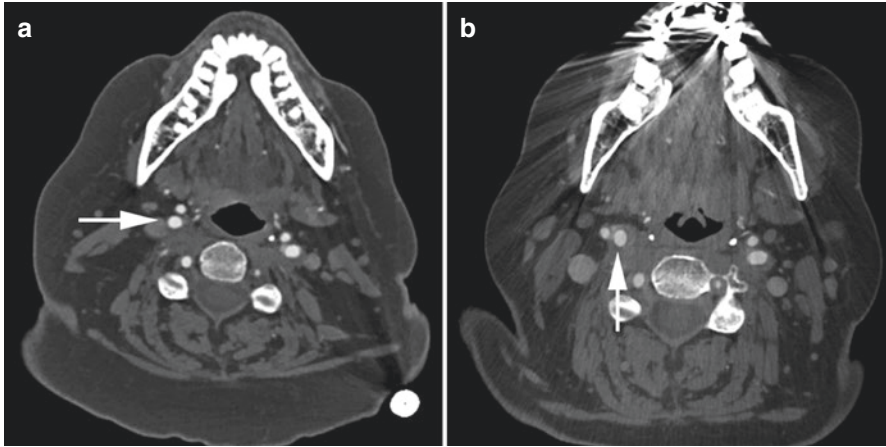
Carotid bifurcation rotation. Two CTA scans 6 months apart showing rotation of the right carotid bifurcation within the carotid sheath. Initially, the right ICA (arrow) was located posterolateral to the ECA (a). On the second scan, the right carotid rotated such that the ICA (arrow) was located medial to the ECA (b)
